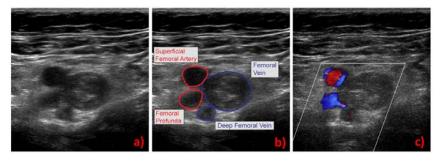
Ultrasound of the right lower extremity was obtained due to asymmetric leg swelling. Figures 6a and 6b demonstrate abnormal heterogeneously increased echogenicity in the femoral vein and deep femoral vein when compared with the adjacent arteries. Figure 6c a color Doppler, shows vascular flow in the arterial system (mixture of red and blue colors) and no flow in the venous system. This is deep venous thrombosis. University of Massachusetts Medical School, Department of Radiology.
